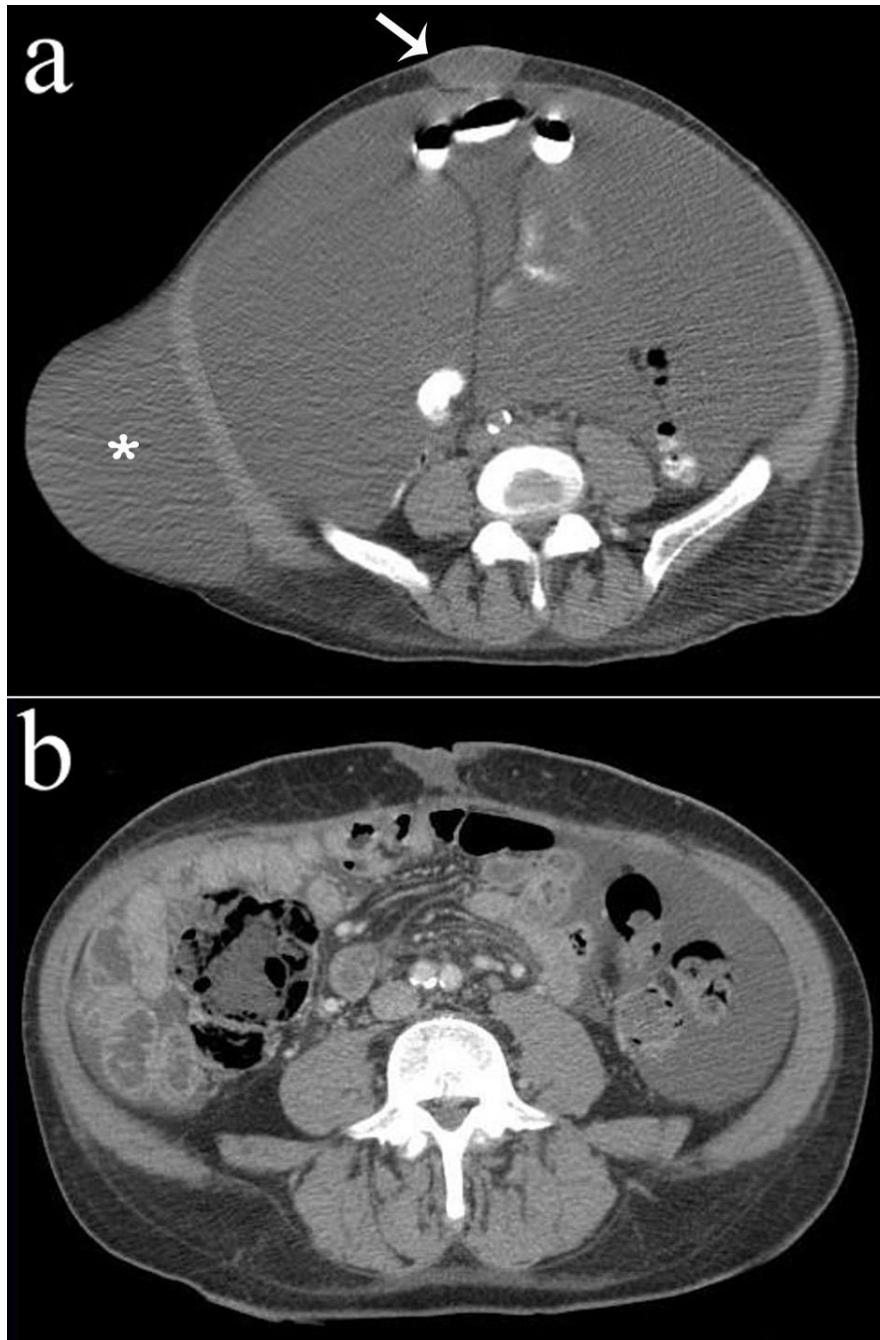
65-year-old man with tense ascites and asymptomatic umbilical hernia who developed severe periumbilical pain, nausea and vomiting, and a tender irreducible umbilical hernia on physical examination within 24 hours after removal of 8L of ascitic fluid. Surgical exploration showed incarcerated umbilical hernia. FINDINGS: (a) Axial non-contrast CT scan (GE LightSpeed Pro 16, Slice thickness: 5mm, kVP:120, mAS:90) of the abdomen few days before presentation shows fluid-filled umbilical (arrow) and flank (asterisk) hernias with no loops of bowel within the hernia sacs. (b) Axial contrast-enhanced CT scan (GE LightSpeed Pro 16, Slice thickness: 2.5mm, kVP:120, mAS:437, 100mL of Isovue-370, venous phase) of the abdomen few days after the surgery showing repaired hernias.
